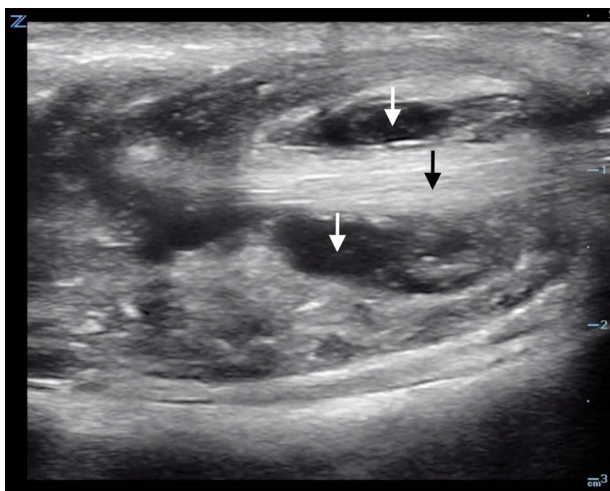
In this longitudinal ultrasound image, complex fluid (white arrows) is seen both superficial and deep to the flexors of the patient's index finger. Note the ragged appearance of the flexor tendon (black arrow).
